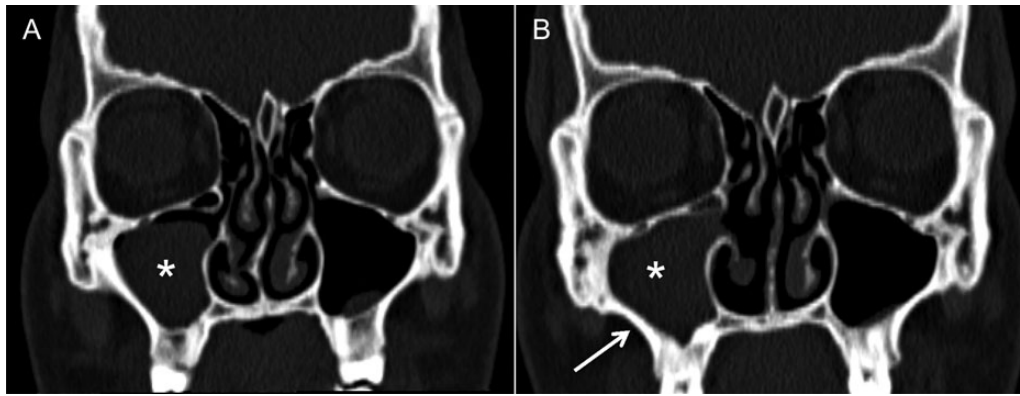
Computed tomography imaging of the paranasal sinuses in the coronal plane. (A) Image performed in 2013 shows subtotal shadowing of the right maxillary sinus by polypoid mucosal thickening (asterisk). (B) Image performed in 2015, postendoscopic infundibulotomy, demonstrates progressive parietal mucosal thickening (asterisk). The lateral wall of the sinus has noticeably thickened (arrow) compared with (A), indicating a chronic sinusitis with consecutive osseous reaction.
